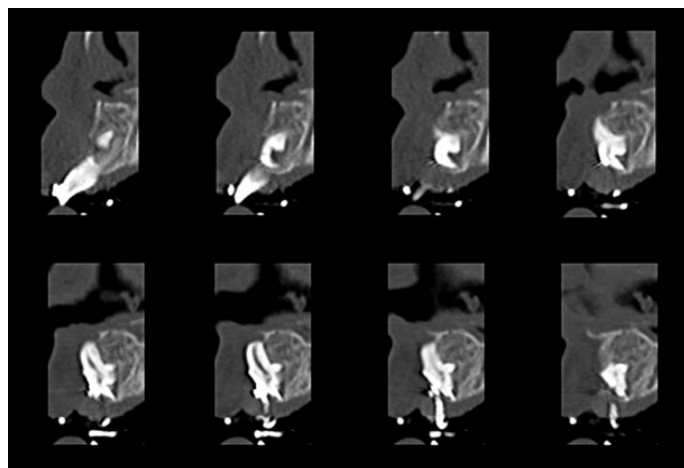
Set of sagittal cross-sections within impacted incisor on the CBCT, showing crown dilacerations
